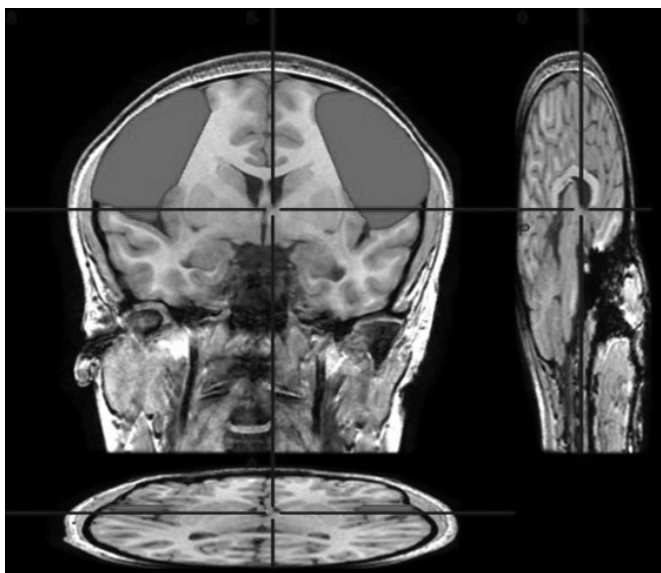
Manual tracing of ten subsequent anterior slices with DLPFC as region of interest using MRI-cro software
